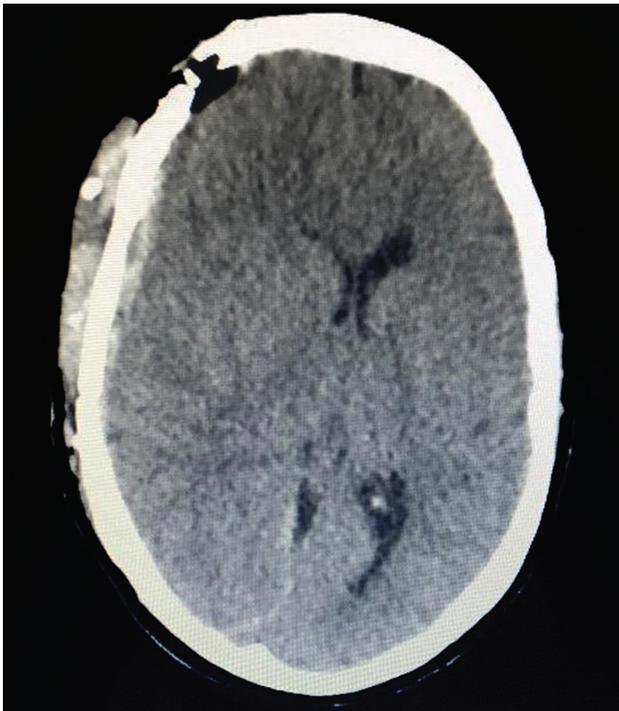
Computed tomography of the skull, axial plane. Computed tomography before craniectomy. Presence of a large right hemispheric edema that increased the shifting of the midline structures and distorted the ventricular anatomy.
